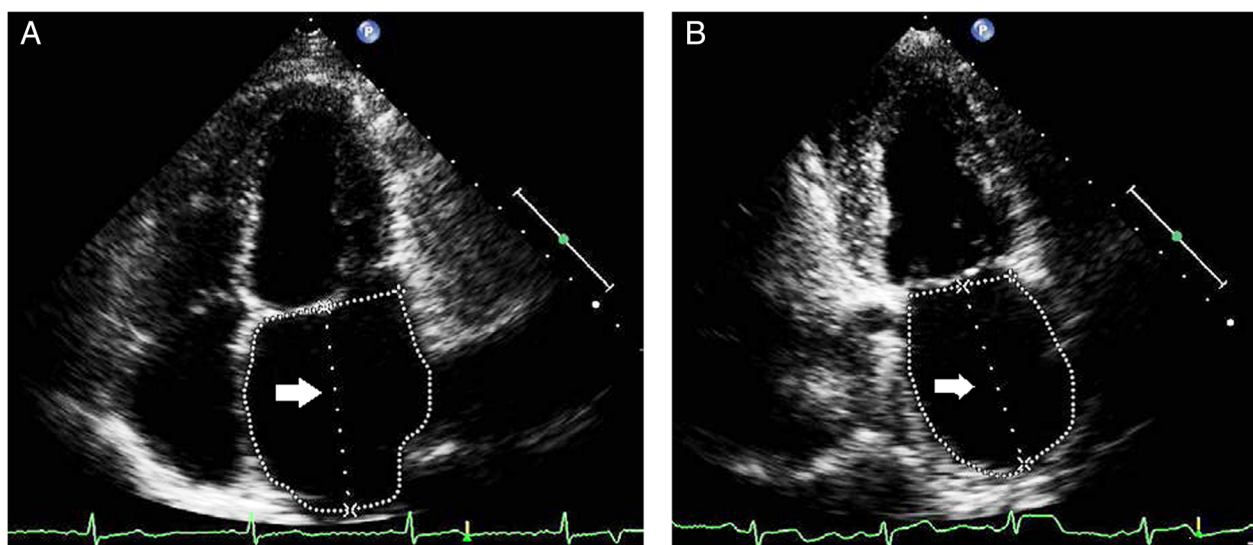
Measurement of left atrial volume from the area-length method using the apical four-chamber (a) and apical two-chamber (b) views. The length (L) is measured from the back wall to the line across the hinge points of the mitral valve (arrow). The shorter (L) from either the A4C or A2C is used in the equation
